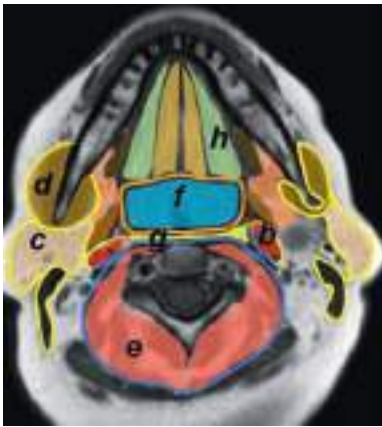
Supra-hyoid neck. (A) Axial T1-weighted MRI at the level of the palate. (B) Axial view at the level of the floor of mouth. Cervical fasciae: I, superficial layer of the deep cervical fascia; II, middle layer of the deep cervical fascia; III, deep layer of the deep cervical fascia. Cervical spaces: a, parapharyngeal space; b, carotid space (retro-styloid parapharyngeal space); c, parotid space; d, masticator space; e, perivertebral space; f, pharyngeal mucosal space; g, retropharyngeal space; h, sublingual space. Anatomical structures: 1, pterygoid muscles; 2, masseter muscle; 3, longus colli muscle; 4, posterior belly of the digastric muscle; 5, sternocleidomastoid muscle; 6, geniohyoid muscle; 7, lingual septum; 8, mylohyoid muscle; 9, submandibular gland; 10, parotid gland (superficial lobe); 11, parotid gland (deep lobe); 12, palatine tonsil; 13, internal carotid artery; 14, buccinator muscle; 15, hard palate; 16, soft palate; 17, semispinalis cervicis muscle; 18, splenius capitis muscle.
